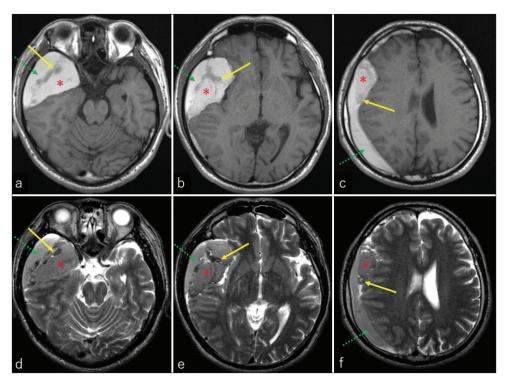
(a-c) Axial T1 and (d-f) T2-weighted magnetic resonance imaging taken at the level of the (a, d) inferior horn of the lateral ventricle, (b, e) third ventricle, and (c, f) upper lateral ventricle showing compressive masses in the right middle fossa (a-f, asterisk) and cerebral convexity (a-f, dashed arrow). The former lesion appears more hypointense, compared to the latter, on both T1- and T2-weighted sequences. Of note, linear structures with varying thicknesses and presenting hypointensity on both sequences can be observed in and around the former lesion (a-f, arrow).
